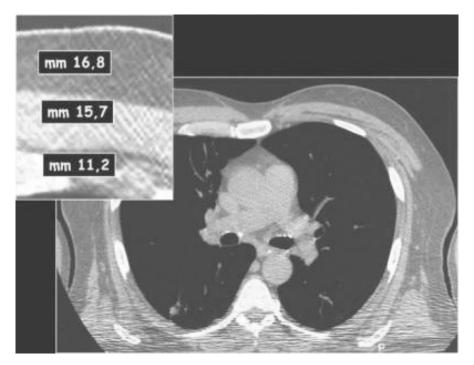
Main panel* Chest CT of a normal subject. The scan was taken at the 2nd intercostal space, with the arms along the body. *Inset* Thickness of the chest wall. Using a normal needle, in case of pneumothorax, an exploratory puncture of the pleural space would have given a false negative result
